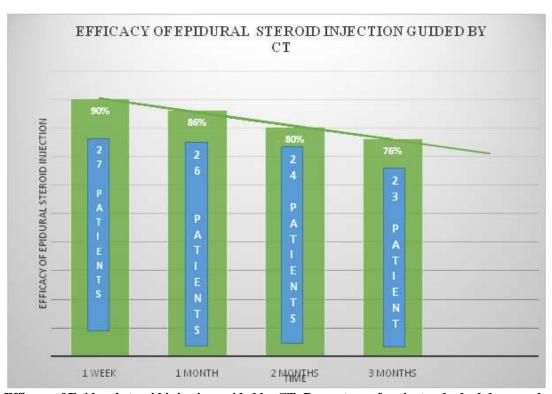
Efficacy of Epidural steroid injection guided by CT: Percentage of patients who had decreased of pain intensity in 50% or more after of the epidural steroid injection
